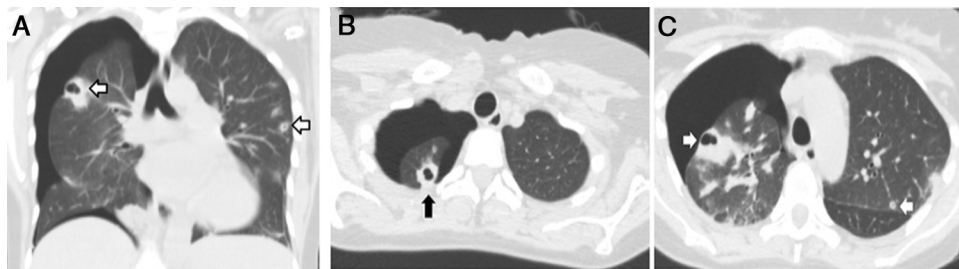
Chest computed tomography: (A) coronal slice; (B and C) transversal slice. Peripheral cavitory pulmonary nodules (arrows) in the right and left upper lobe and right pneumothorax.
